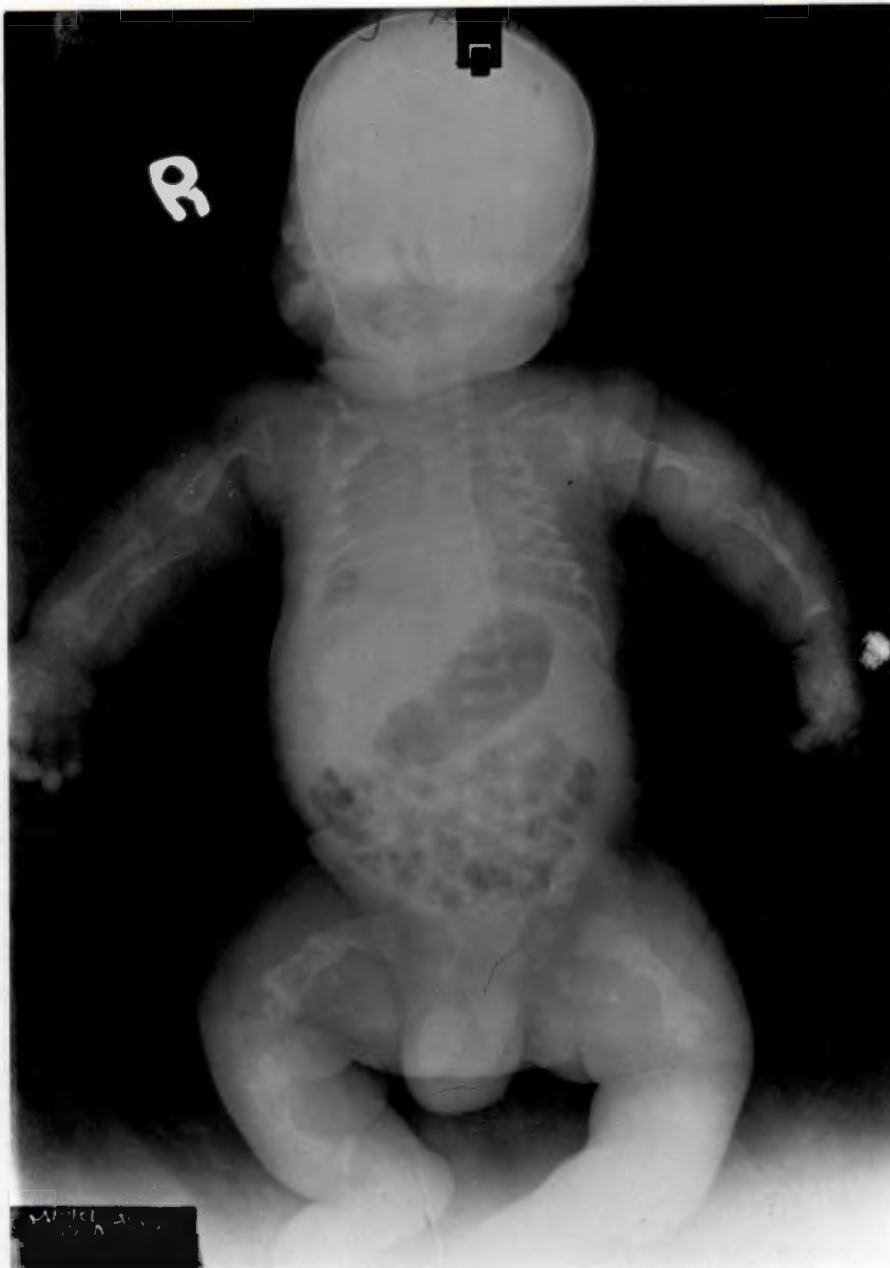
Radiograph of a neonate with the presumptive diagnosis of lethal OI: thin ribs and "apple-core" femora are evident.
